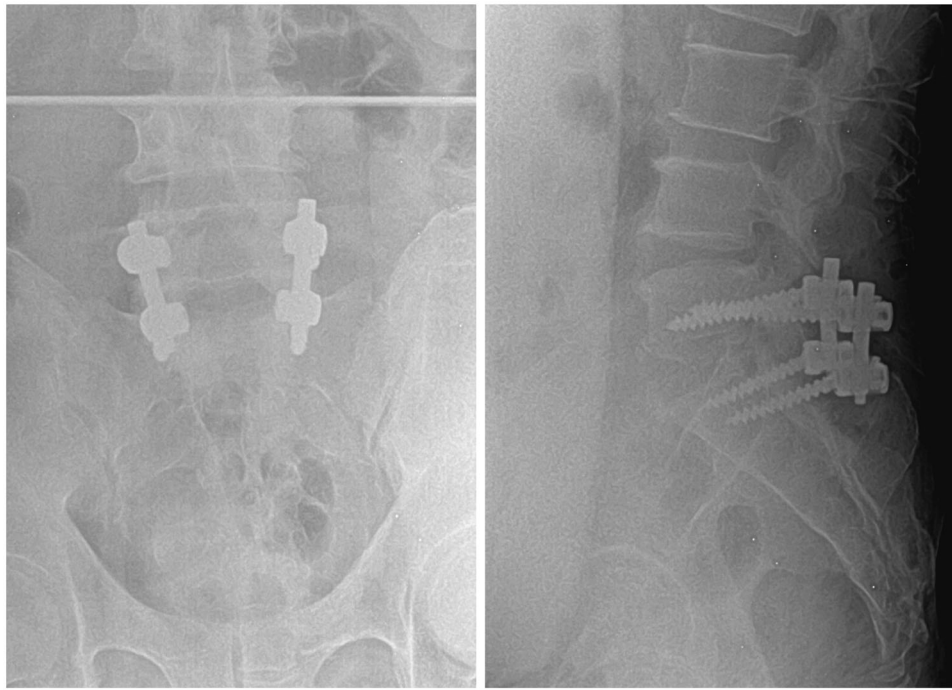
Case 2. Postoperative coronal CT (Left) and sagittal CT (Right) showing the internal fixation in the good position.
